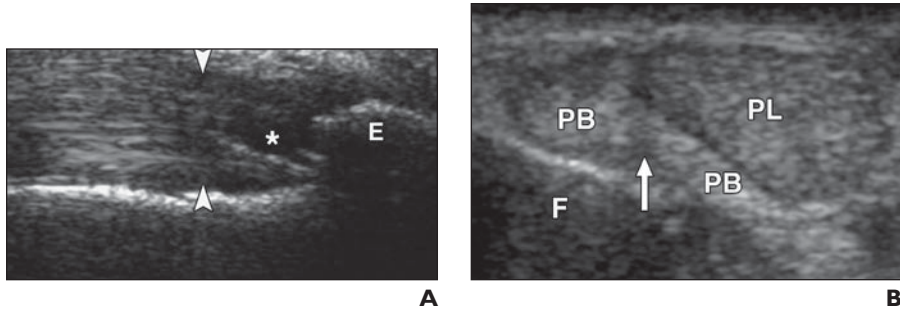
68-year-old man, runner in Senior Olympics, has been experiencing ankle pain. Sonography was ordered to “rule out Achilles tendon tear.”
